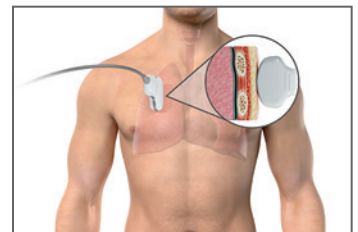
Placement of the Transducer during Lung Ultrasonography.
